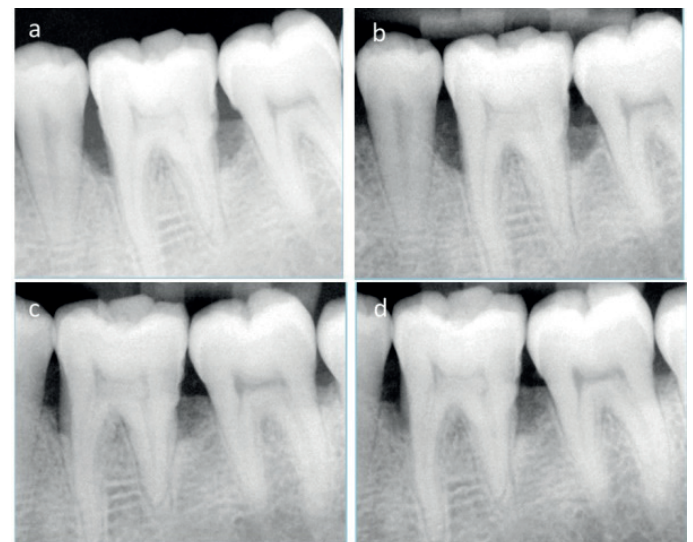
Test site radiographic evaluation at baseline (a), three months (b), six months (c) and 9 months (d).
